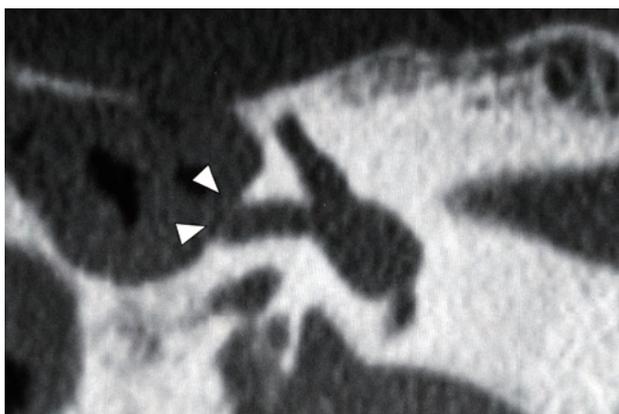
The coronal CT scan clearly showed the inner ear fistula in the lateral semicircular canal (arrow head).
